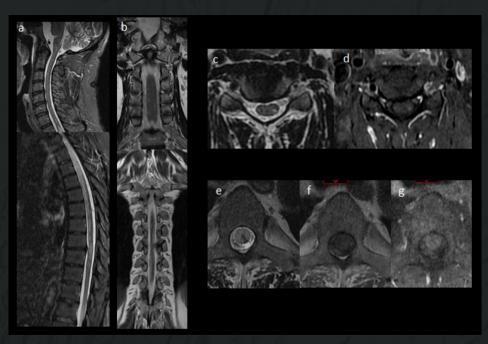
51 year-old male with COVID-19 pneumonia and paraparesis. Whole spinal cord MRI. Sagital (a) and coronal (b) T2-weight image, axial T2-weight image (c, e) and T1 pre (f) and post-contrast (d, g) on 1,5T MRI. Multiple high T2 signal lesions that involve mainly the lateral cords of the cervical and dorsal spinal cord with a swollen and confluent appearance from C7 to T7 with irregular enhancement after intravenous gadolinium administration.
